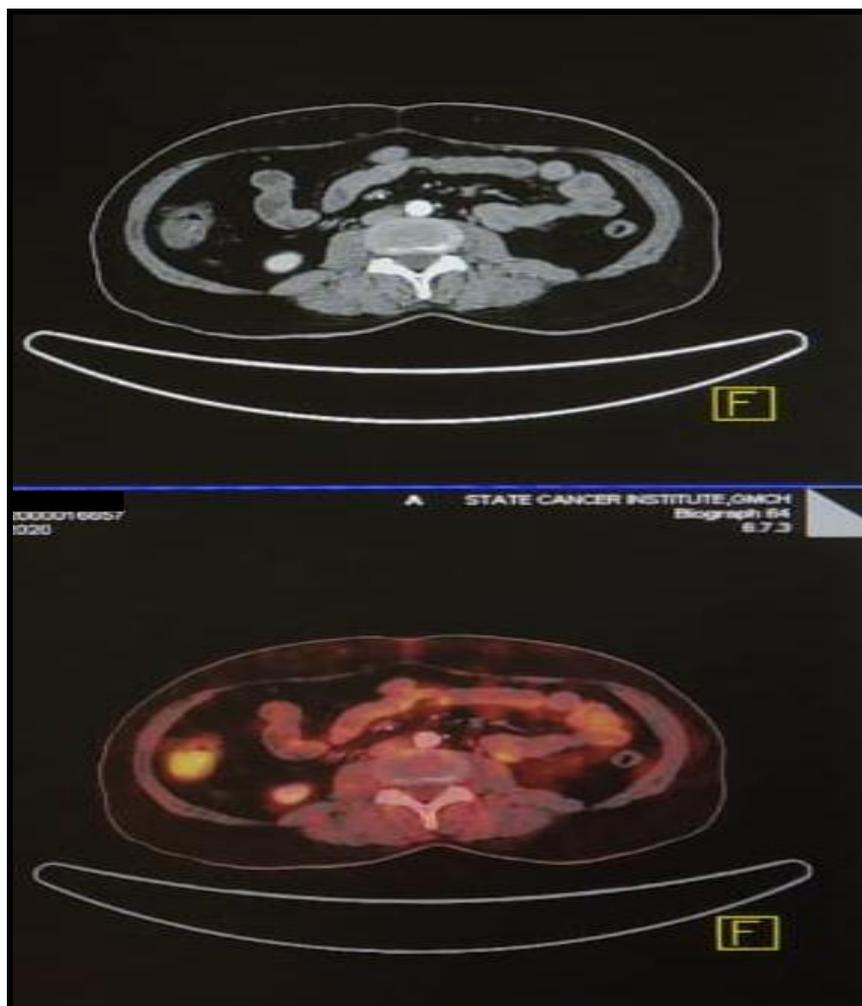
A case of DLBCL with FDG avid cervical, axillary, abdominal and inguinal lymph nodes not taken any treatment: evaluated for initial staging (stage III).
